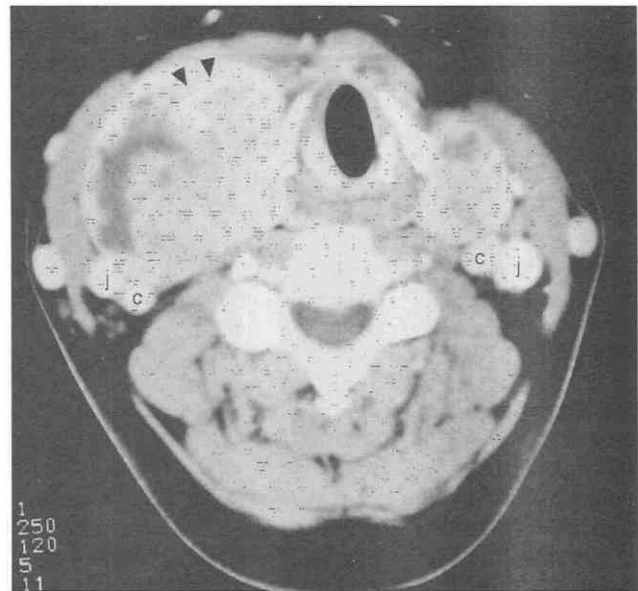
Multinodular goiter. CT scan at the level of the cricoid cartilage shows bilaterally enlarged, heterogeneous thyroid lobes. Several foci of calcification (arrowheads) are seen within the larger right lobe. The common carotid arteries (c) and internal jugular veins (j) are displaced posterolaterally.
